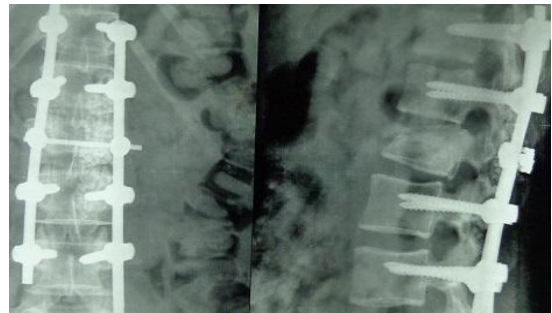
AP and Lateral X-ray after 6 weeks
